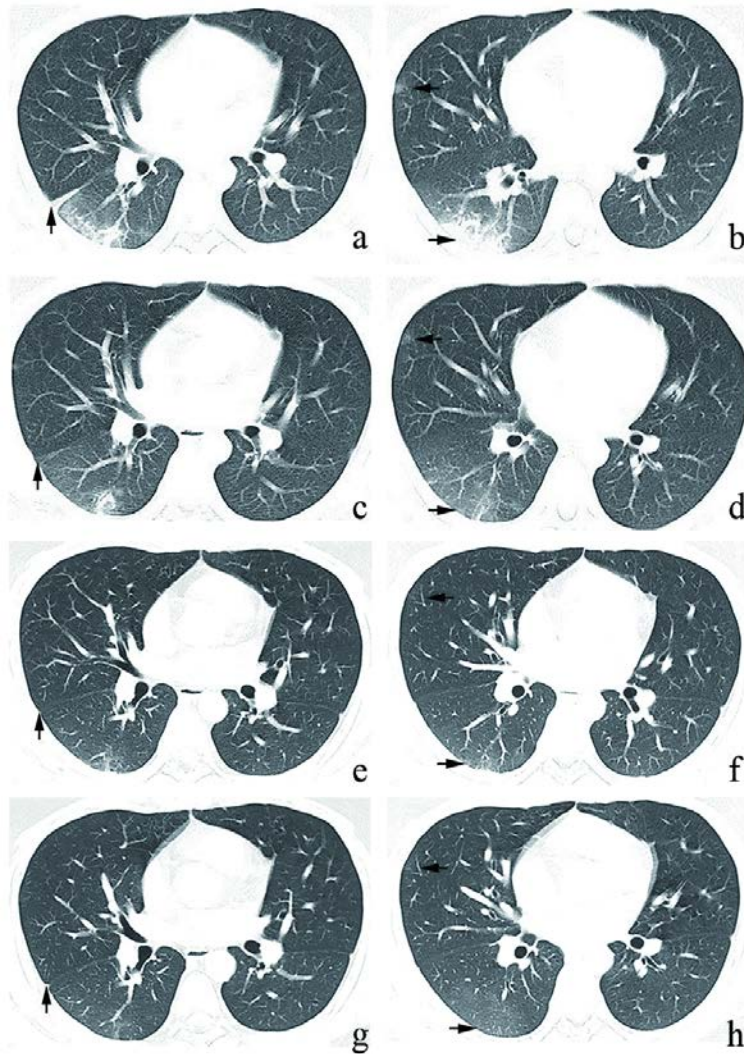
Chest CT images of the HIV-infected patient with COVID-19.
